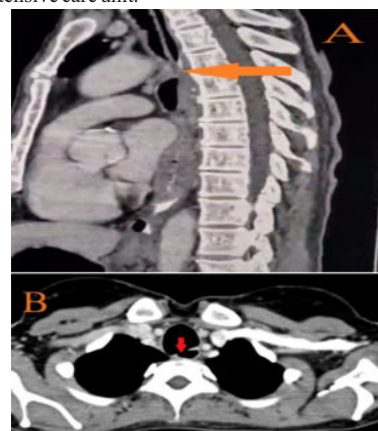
Contrast enhanced Computed tomography of thorax showing trachea-esophageal fistula (coloured arrow) in advanced esophageal cancer. A. sagittal view, B. axial view
